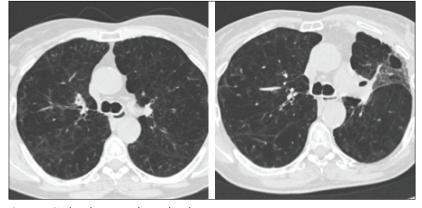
AeriSeal emphysematous lung sealant therapy Axial CT scan before (left) and after (right) treatment with sealant to the lingual segment, with development of ground glass change and fibrosis.
